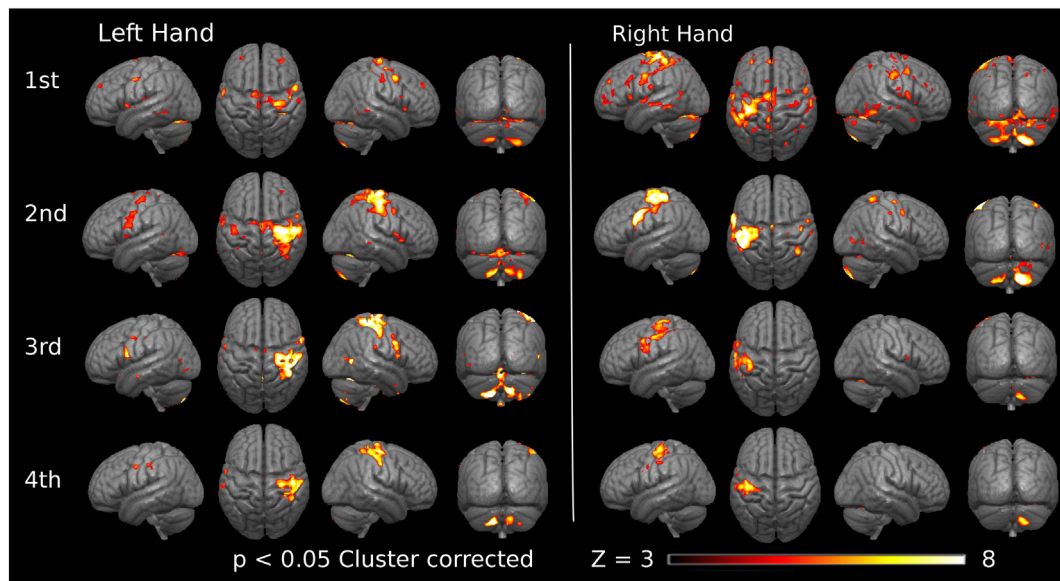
Cortical activation during the movement of the transplanted hands. Rows indicate the time point of MRI acquisition across four consecutive years. In the top and posterior views the right hemisphere is represented on the right.
